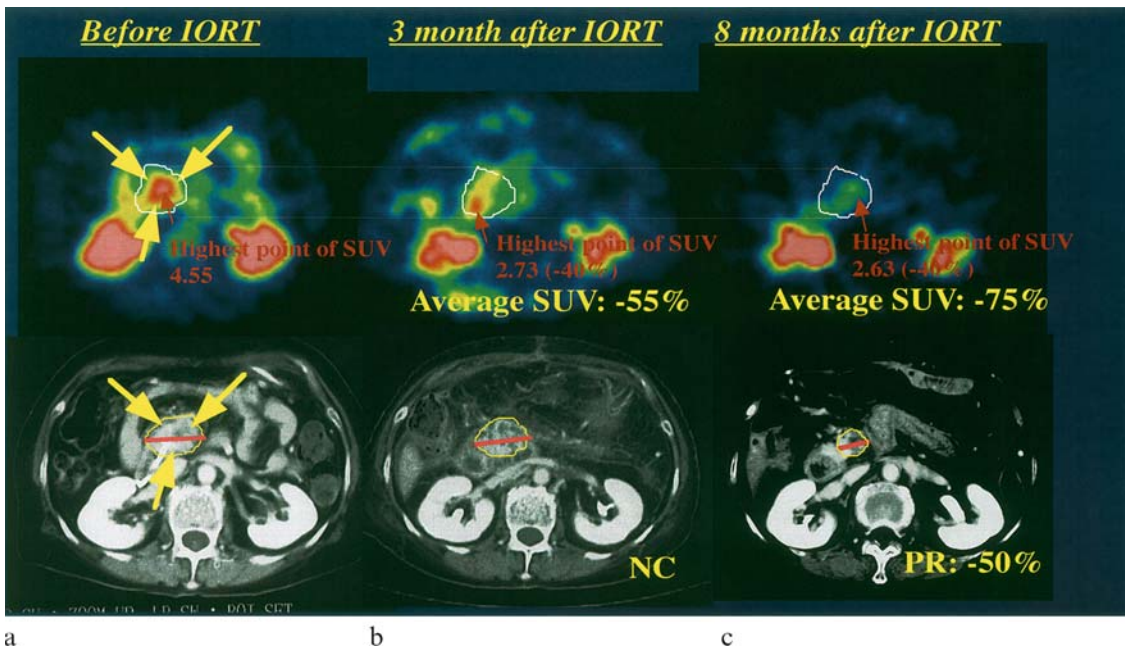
Evaluation of therapeutic effect of IORT and EBRT by FDG-PET. Seventy-three years old female patient with unresectable pancreatic cancer without distant metastasis was initially treated with IORT (30Gy) and then followed with EBRT (50.4Gy). PET and CT studies were performed before treatment (a) 3 months after IORT and just after the end of EBRT (b) and 8 months after the IORT (c). The decreased FDG uptake was observed at 3 months after IORT, whereas CT findings did not show any change in size at that time. Eight months after IORT, tumor finally showed decrease in size at CT. PET showed marked decrease in FDG uptake around the pancreatic head in general, but there was an intense hot spot remained, which suggest viability within the irradiated mass. This patient died 4 months later after this PET study because of multiple liver metastasis. *IORT: intraoperative radiation therapy EBRT: external beam radiation therapy*
